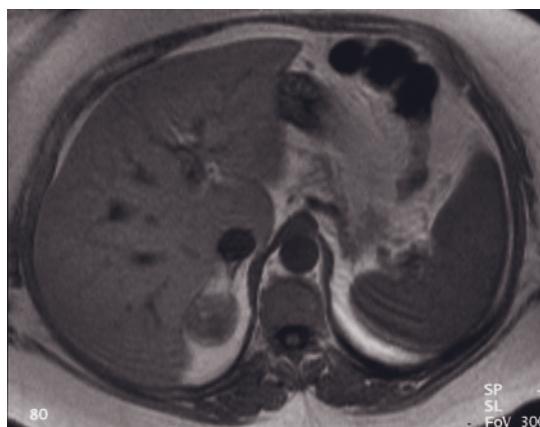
Bilateral adrenal adenomas. T1-weighted GE (a), T1-weighted out-of-phase GE (b), T2-weighted echo-train spin-echo (c), immediate postgadolinium GE (d), and 90-s postgadolinium fat-suppressed GE (e) images in a patient with bilateral adrenal adenomas. Bilateral adrenal adenomas drop in signal intensity from in-phase (a) to out-of-phase (b) images, and they are mildly hyperintense relative to liver on the T2 image (c). The right adrenal adenoma has an early intense capillary blush, whereas the left adrenal enhances to a lesser extent immediately after gadolinium administration (d). The bilateral adenomas are hypointense on the late fat-suppressed image (e).
